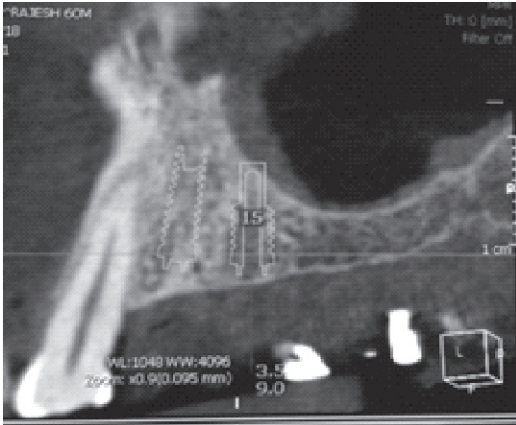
CBCT of the arch showing implant impinging on sinus
